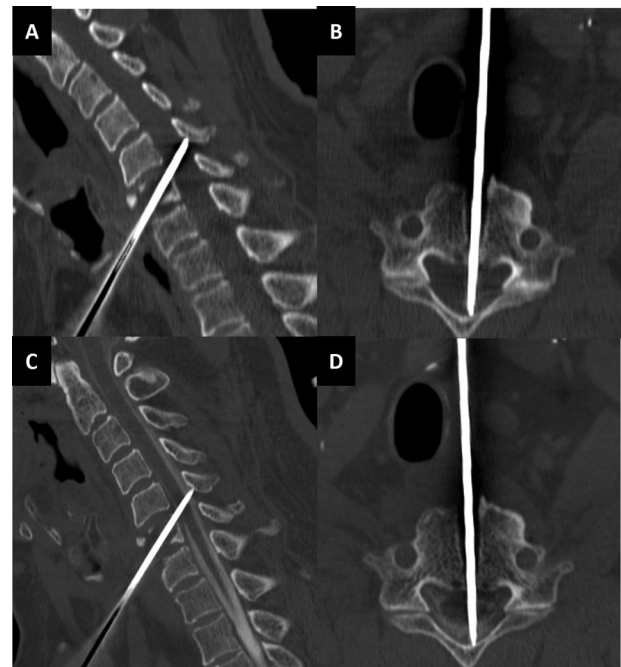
A plain CT of the cervical spine shows that the K-wire had penetrated the C6 vertebra and that the tip of the K-wire was located in the spinal canal (A, B). CT myelography shows the penetration of the spinal cord by the K-wire at the C5-6 level (C, D).
